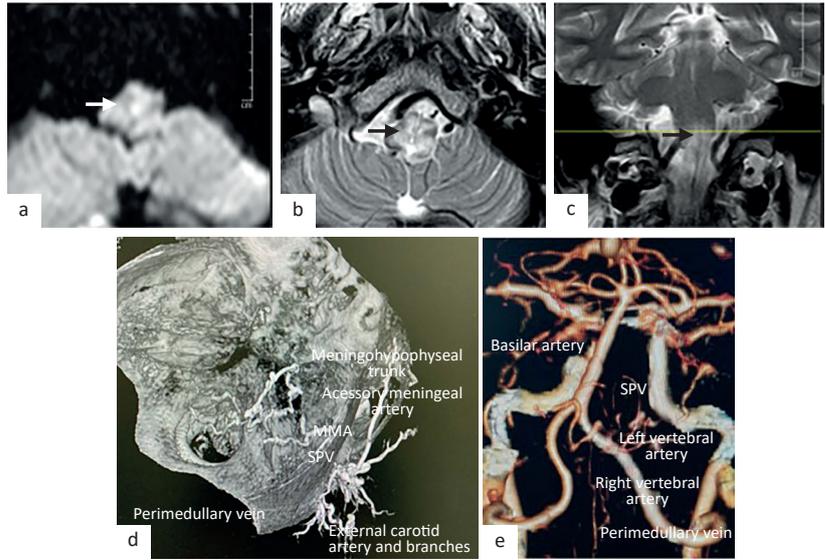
Cerebral imaging. Brain MRI with normal intensity signal (white arrow) at axial DWI (a) and high intensity signal (black arrow) at T2-weighted sequence (b) at the level of medulla oblongata, as showed at coronal section (black arrow) (c). Cerebral CT angiography with right anterior oblique view of 3D bone reconstruction (d) and 3D CT angiogram (e) showing early filling of perimedullary vein during arterial phase. CT=computed tomography; DWI=diffusion-weighted imaging; MMA=middle meningeal artery; MRI=magnetic resonance imaging; SPV=superior petrosal vein
